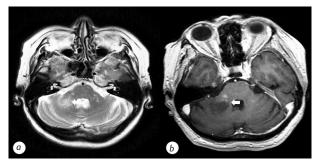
MRI scan results on 13.05. Hyperintense lesions can be seen on T2 FLAIR bilaterally in the cerebellum peduncles. Lesion in the right peduncle has central cystic component (white arrow). Another contrast-accumulating lesion is located in the frontal lobe. Differential diagnosis can be made between encephalitis with paraneoplastic syndrome or PML with perivascular lymphocytic infiltration: a-T2 axial FLAIR; b-T1 3D
